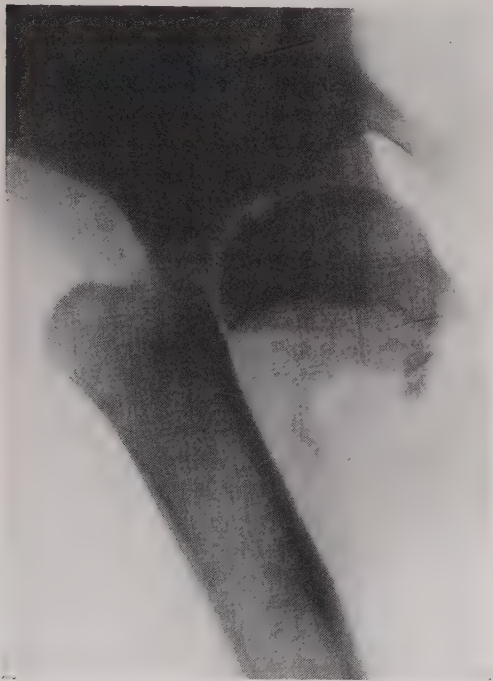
Roentgenogram of separation of the upper humeral epiphysis. Axillary view. (Fracture Service, M. G. H.)
